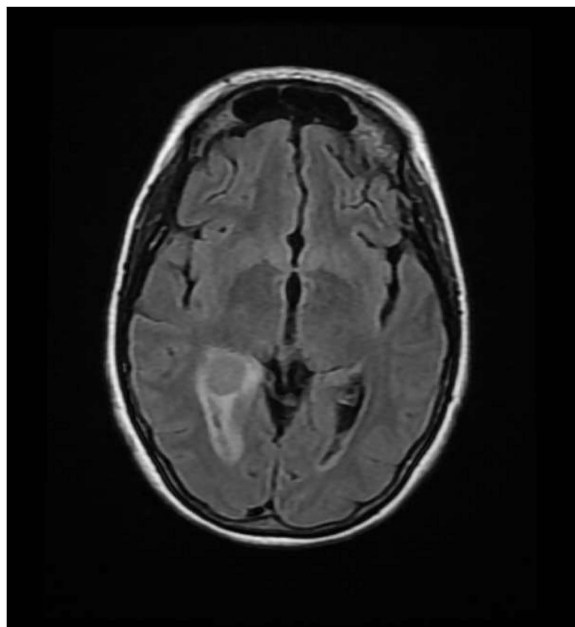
MRI which shows right temporal mass.
